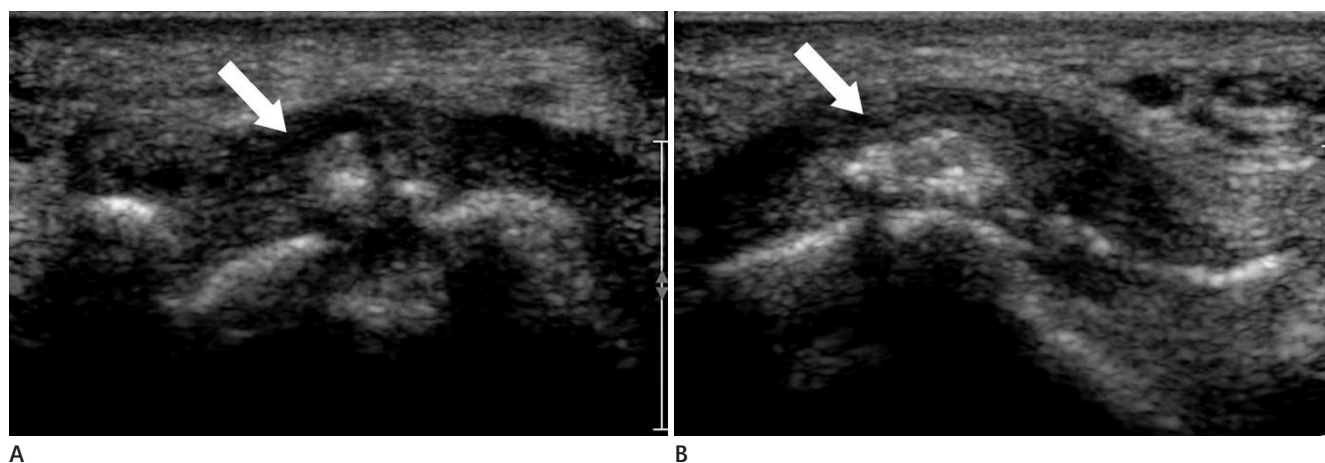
Ultrasonography of the right foot. A. A transverse scan shows multiple echogenic nodules of the medial sesamoid (arrow) with fragmentation. B. A longitudinal scan shows an irregular surface of the medial sesamoid (arrow) with multiple echogenic nodules.
